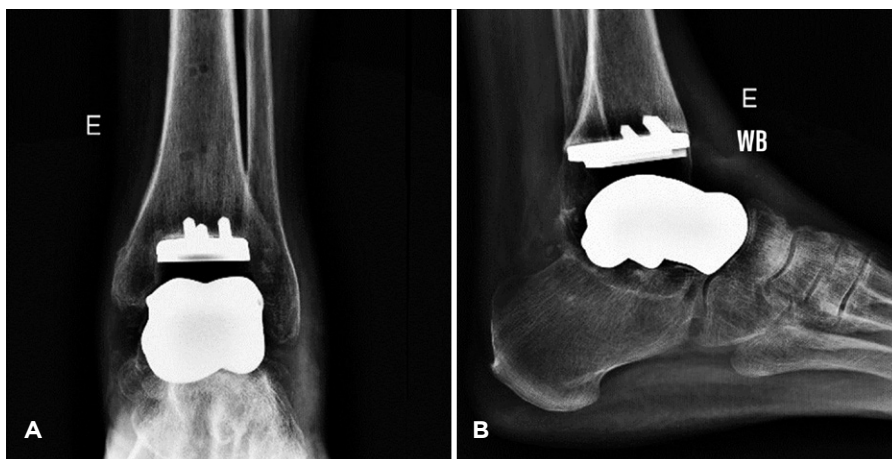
Radiographs showing the alignment of the implants were maintained. A) Anteroposterior radiography of the ankle. B) Profile radiography.
